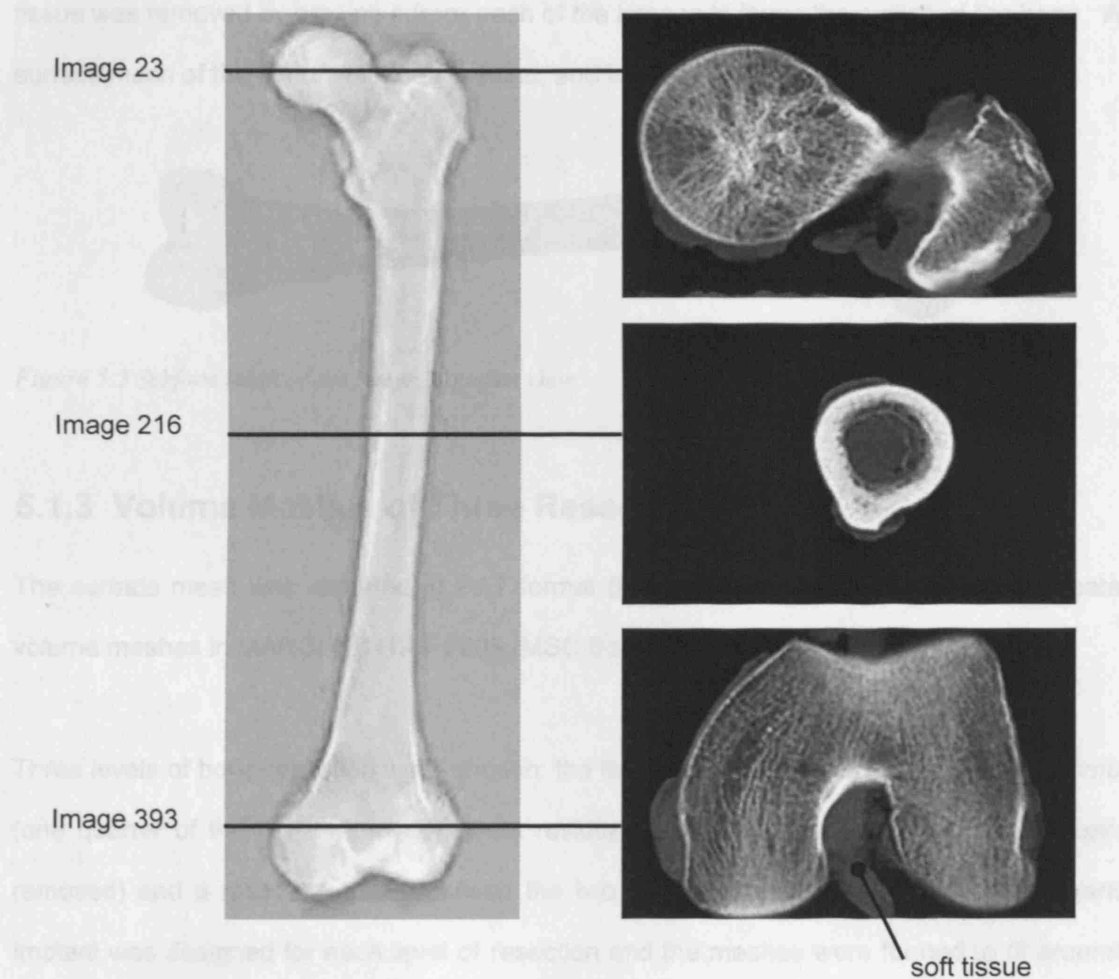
Examples of the CT scans taken at different levels of the femur.
